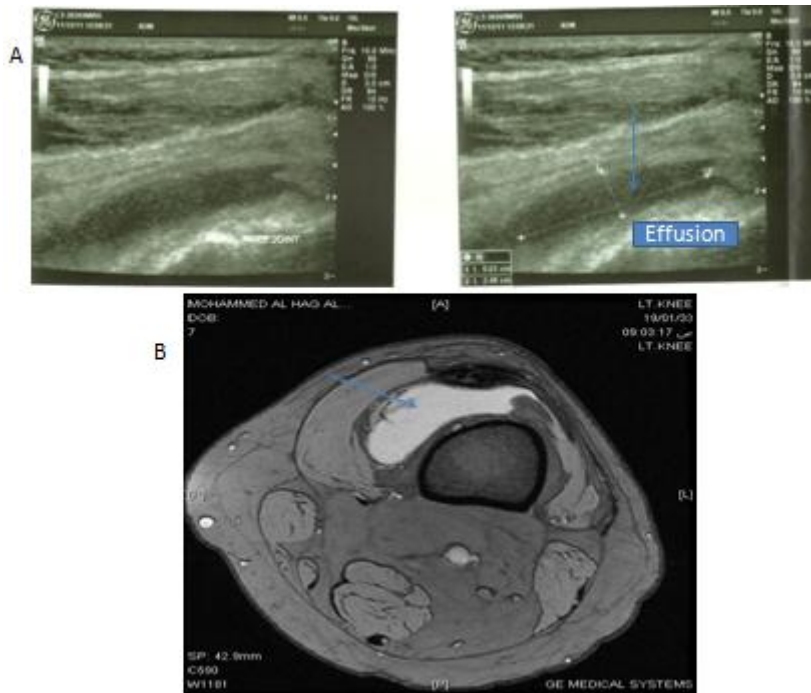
Knee joint Effusion, Ultrasound: A, MRI: B
